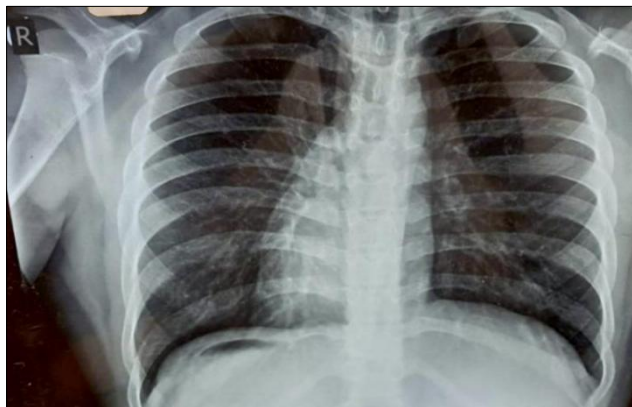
Xray chest (PA view). The heart is on the right side of chest - Dextrocardia with right sided gastric bubble. The aortic knuckle is seen on the left side. Moreover, the pulmonary blood flow is decreased.
